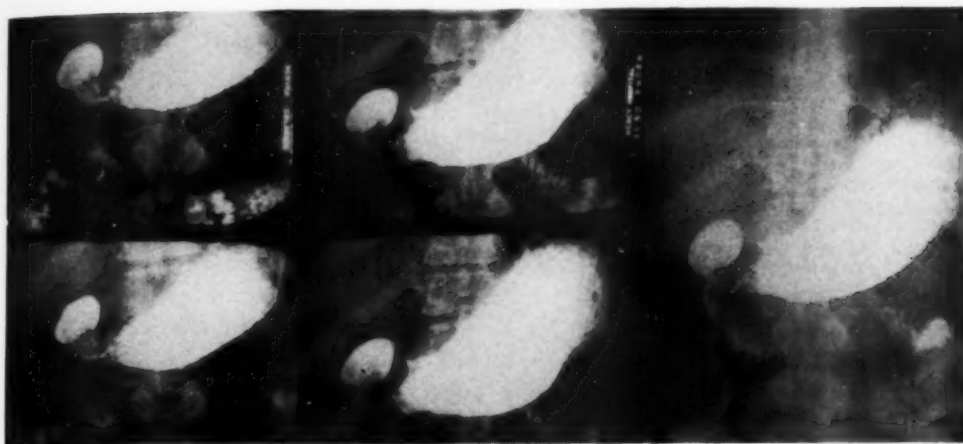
Case I. Roentgen picture indistinguishable from carcinoma or gastritis, due to adhesions secondary to gallbladder disease.
